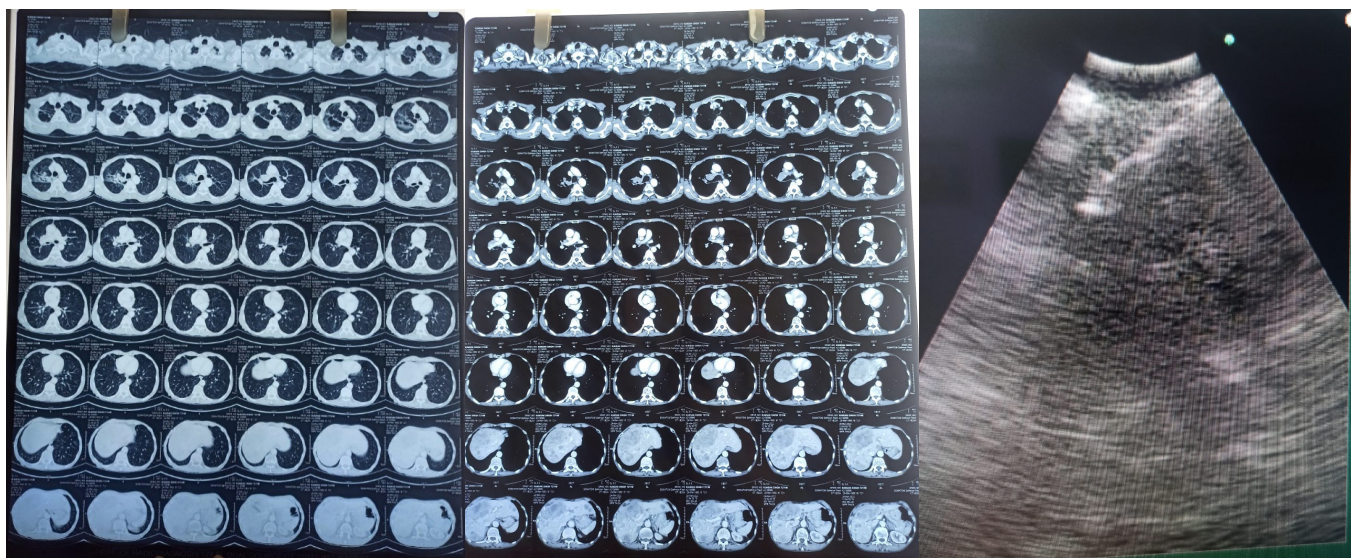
Endoscopic ultrasound shows 4R lymph node from which sample was taken
